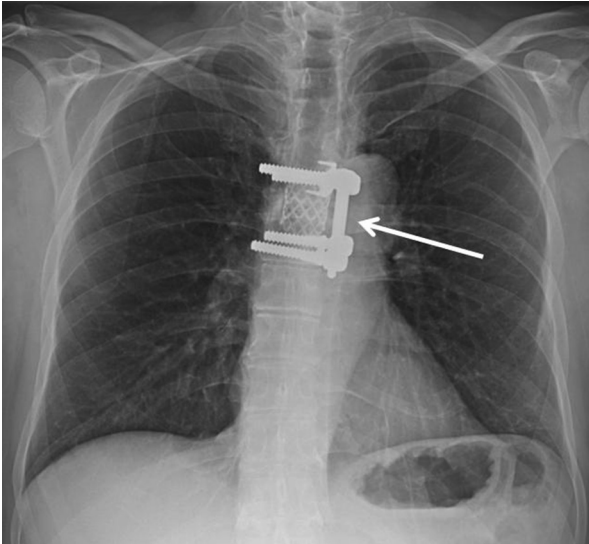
Chest x-ray study demonstrating vertebral screws at T5–7 with lateral rod fixation (arrow).
